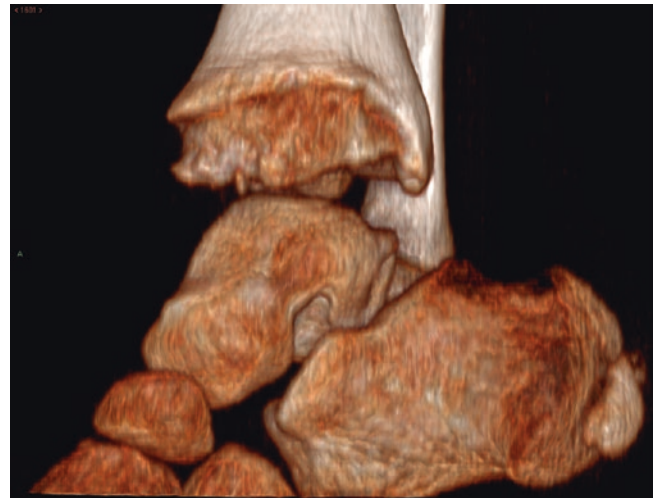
3D CT reconstruction of the ankle joint in the same child showing abnormality of the distal tibial physis
